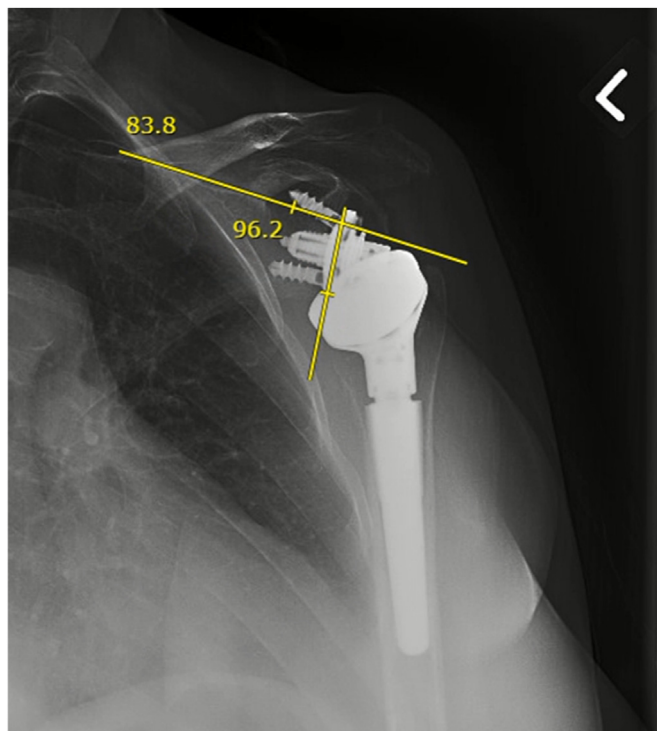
Reverse shoulder angle measured at the 6 months x-ray.
